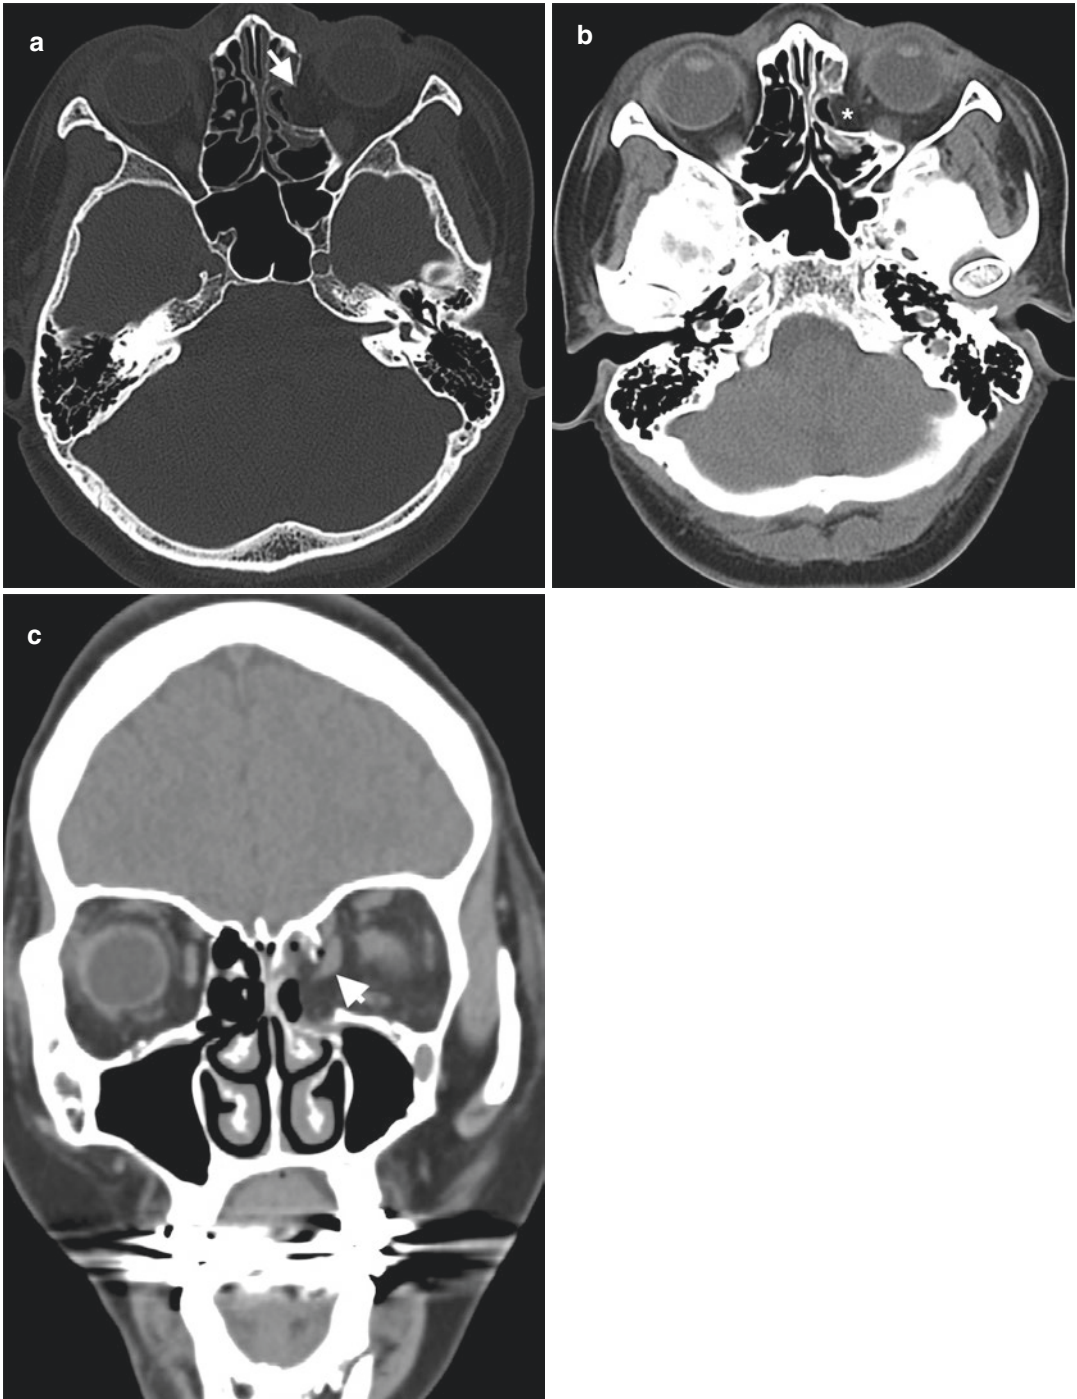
Blow-out fracture. (a) Axial CT image of a 39-year-old woman with a history of fall demonstrates a medial orbital wall defect (arrow). (b) Axial CT image on soft-tissue window reveals herniation of extraconal fat (*)
